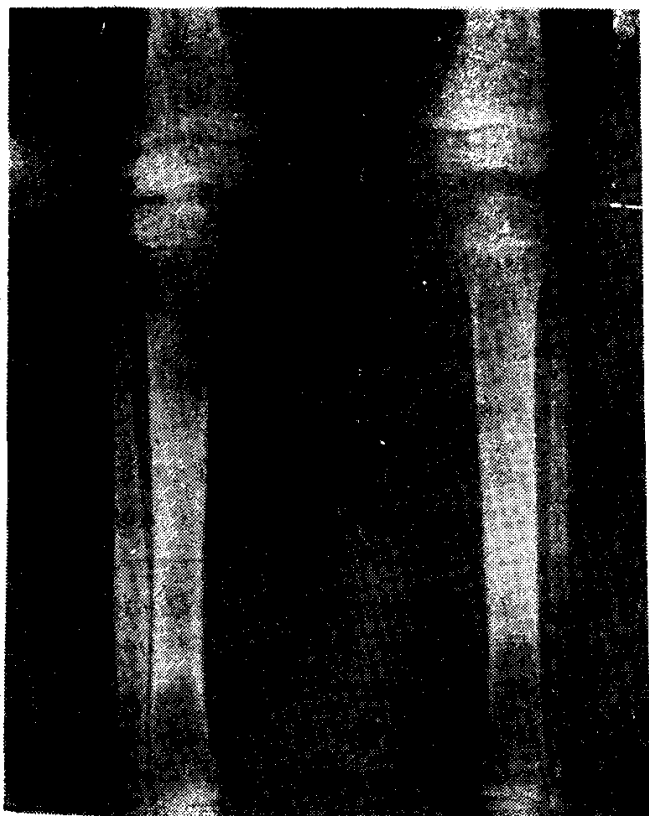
Xrays of the legs after treatment. There is significant improvement of the lesions.
